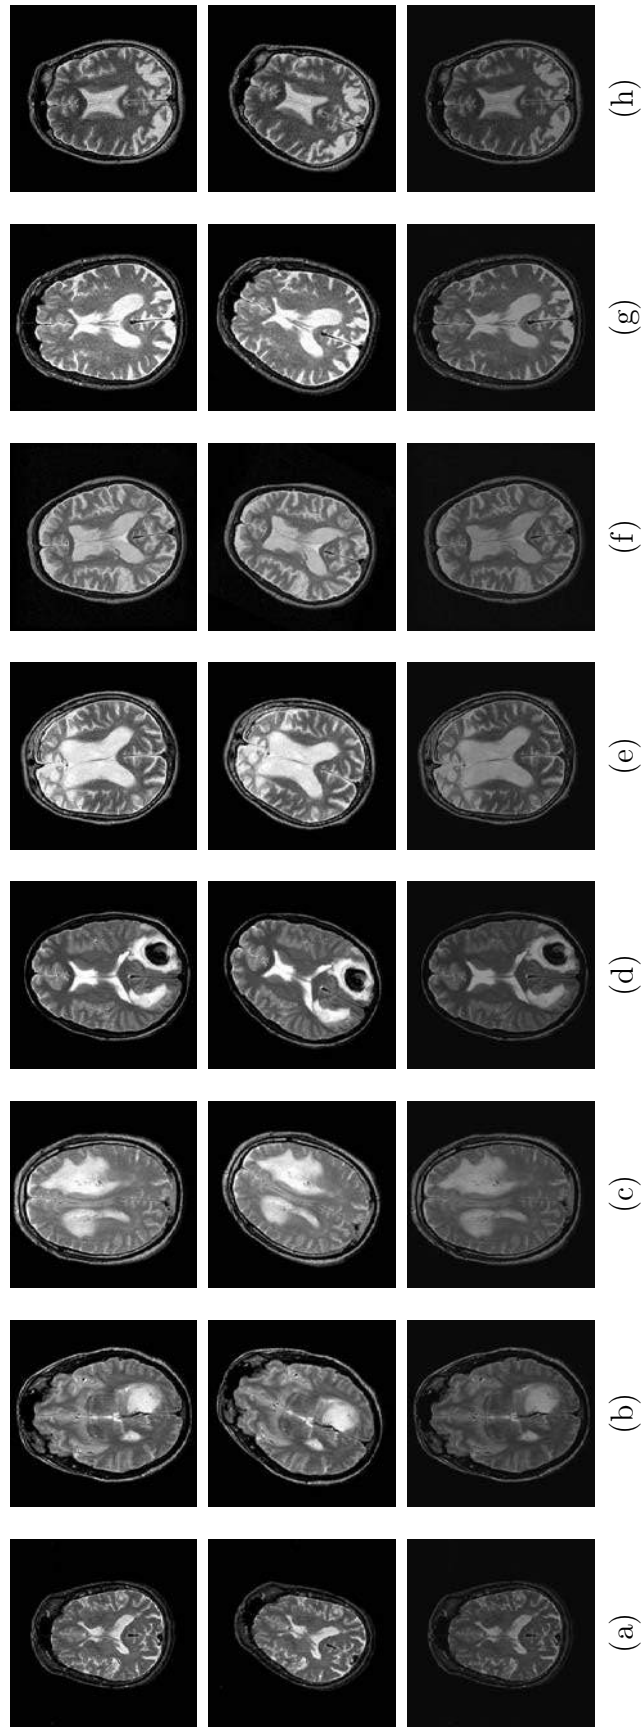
Sample brain MR images used in the experiments of ‘*Scheme 2*’ (row 1) with corresponding rotated (row 2) and dynamic range (row 3) modified versions: (a) normal, (b) glioma, (c) meningioma, (d) sarcoma, (e) Pick’s disease, (f) Huntington’s disease, (g) Alzheimer’s disease, (h) Alzheimer’s disease with visual agnosia.
